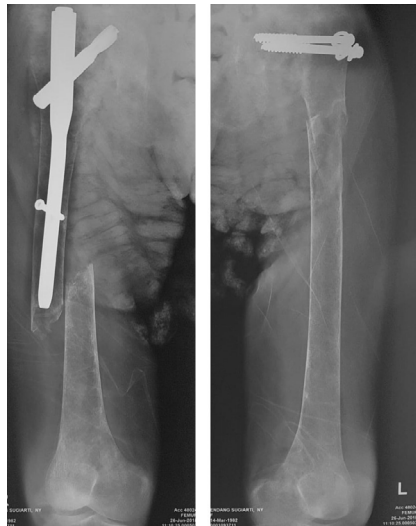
X-ray bilateral femur, a deformity in 1/3 right femur with internal fixation and complete fracture, as well as a deformity in the left femur with internal fixation and fracture.
